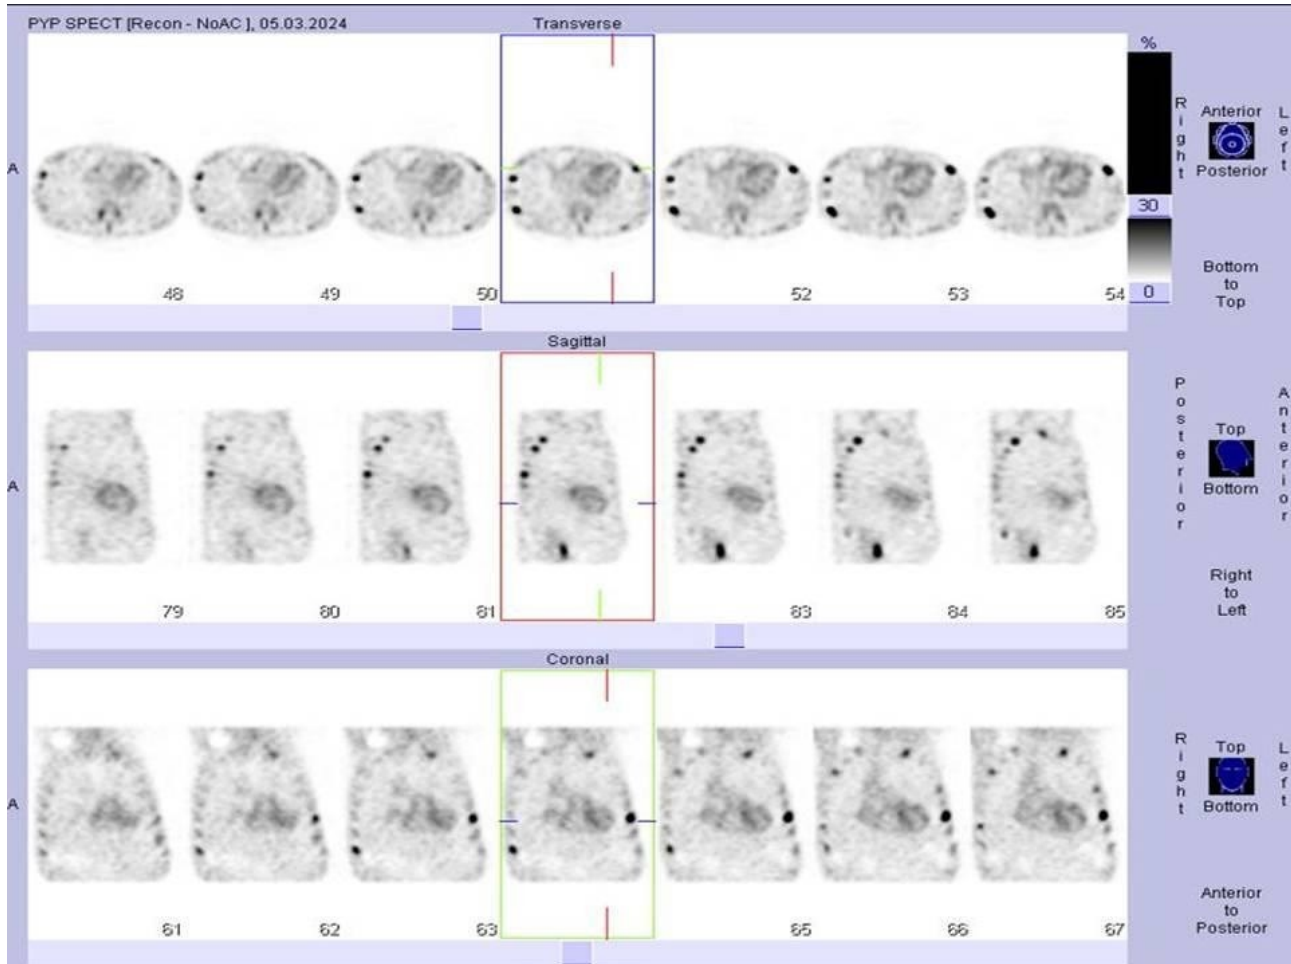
1st hour SPECT imaging of a 90-year-old male patient whose cardiac involvement was scored as Grade 3. In this patient, we additionally observed activity involvements in areas corresponding to the ribs that may be compatible with fractures, and we took this into consideration when making a visual evaluation.
